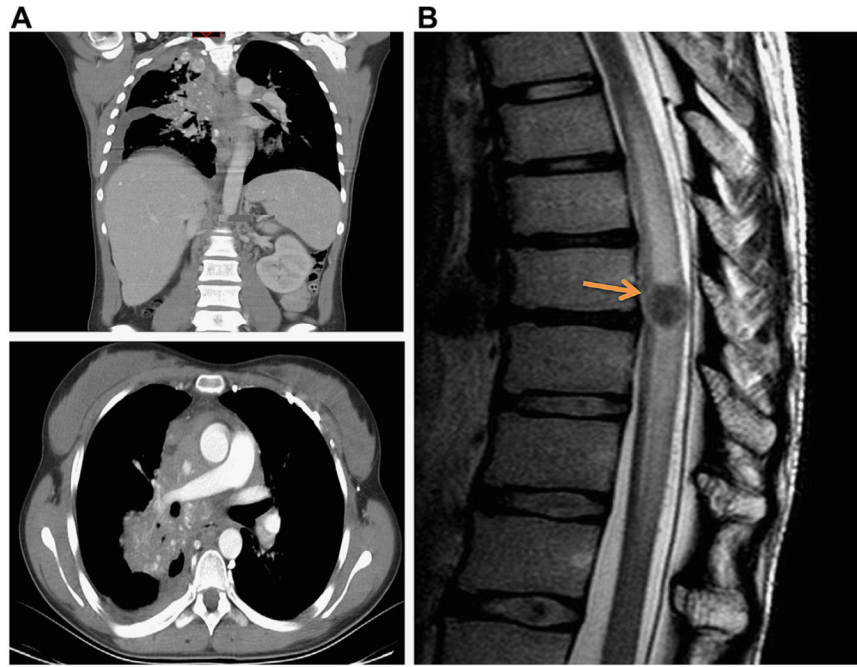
Patient 1. A, Extensive right upper lung, mediastinal, and pleural involvement with *C immitis*. B, MRI showing an intramedullary spinal cord lesion (*arrow*) with edema and cord compression.
